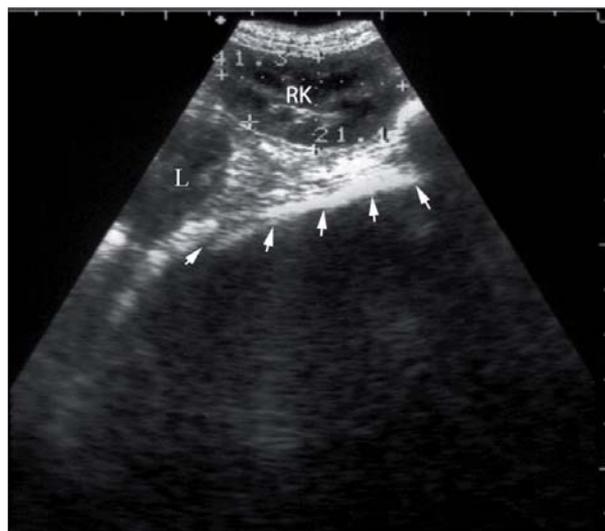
Longitudinal ultrasound image of the right perirenal fat depot (white arrows) in a New Zealand white rabbit with body weight of 3.0 kg. RK: right kidney, L: caudate lobe of the liver.
